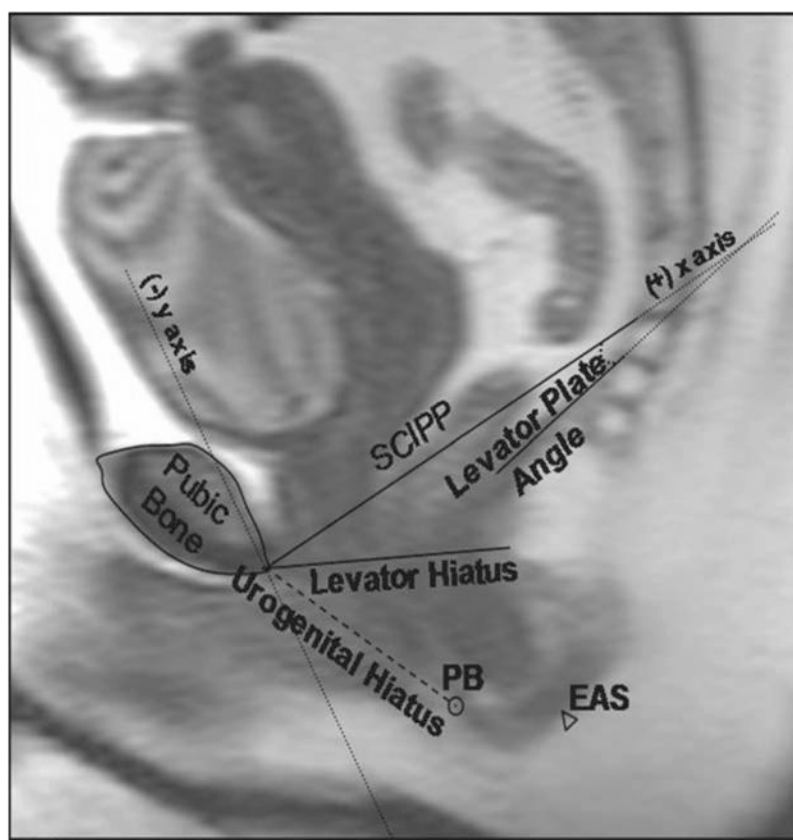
Mid-sagittal MRI showing locations of perineal structures at rest. The SCIPP line is shown (x-axis). The pubic bone, levator plate angle, levator hiatus and urogenital hiatus are also shown. The perineal body (PB) and external anal sphincter (EAS) are demonstrated as well.
